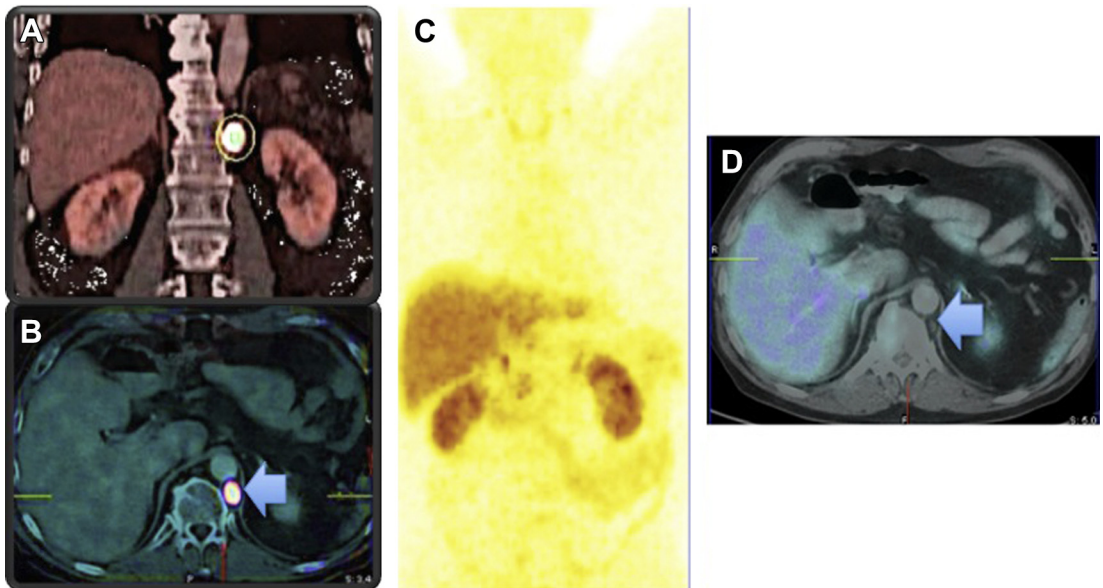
A 66-year-old patient with well-differentiated, nonfunctioning NET of the pancreas, status post left pancreatectomy, splenectomy, and also metastasectomy in segment 2 of the liver was referred for follow-up ^{68}Ga -SSTR PET/CT after surgery, which revealed a single, very intensely SSTR-positive retrocrural lymph node metastasis with an SUV of 152. Based on this, he underwent 2 cycles of PRRT with 14 GBq ^{177}Lu -DOTATATE. The very high receptor expression and uptake of ^{177}Lu and the resulting high dose delivered to the metastasis resulted in a complete remission according to molecular response criteria, after the 2 PRRT cycles. (A) Fused coronal ^{68}Ga -DOTATATE PET/CT before therapy and (B) fused transverse image before therapy showing the lymph node metastasis with a circle and arrow, respectively. (C) MIP image of ^{68}Ga -DOTATATE PET/CT after 2 therapy cycles and (D) corresponding fused transverse posttherapy image confirmed molecular complete remission, although a small lymph node (arrow) is still noted on the CT, which remained stable in size over the next years of follow-up.
